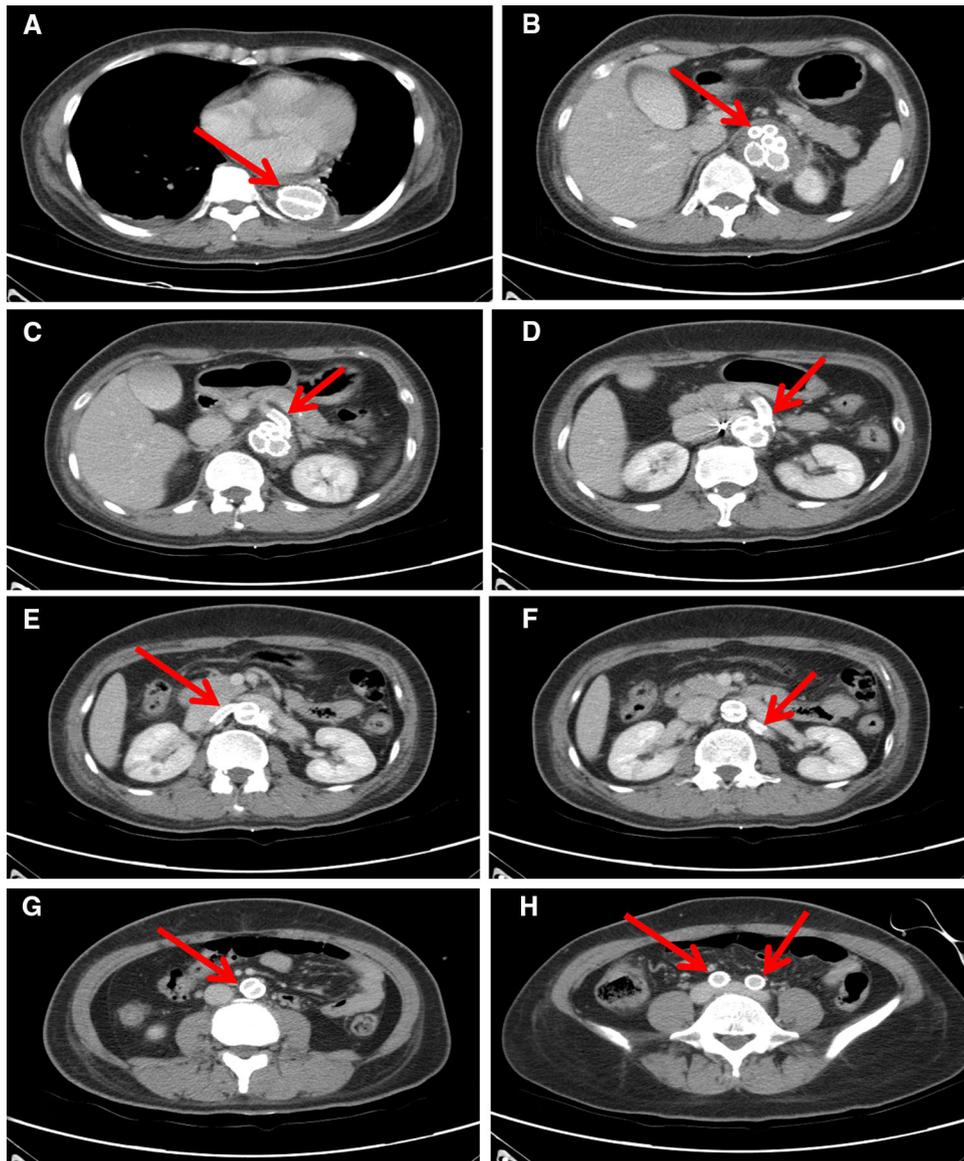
Postoperative computed tomography angiography of the aorta. A The red arrow depicts double-barreled main body stentgraft in the thoracic aorta. B The red arrow depicts four renovisceral stentgraft from two contralateral limbs. C The red arrow depicts the stentgraft in the celiac trunk with good patency. D The red arrow depicts the stentgraft in the superior mesentery artery with good patency. E The
